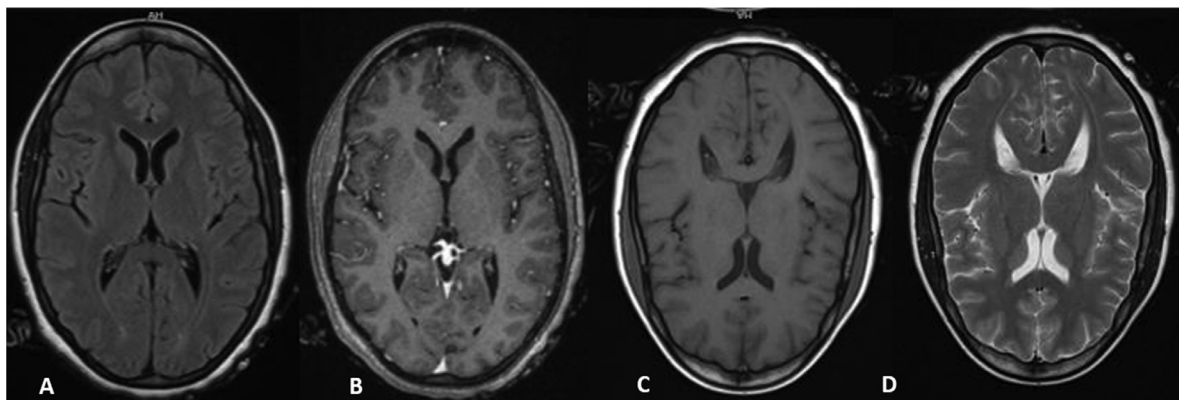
Admission MRI shows focal lesions in both basal ganglia regions in deep, thalamic location, (A) T1 axial T1-weighted image (B) T2 axial T1-weighted image (C) FLAIR image (D) contrast-enhanced image.
